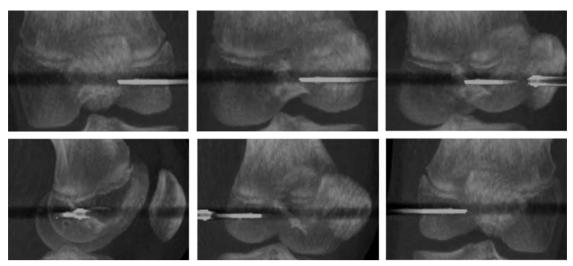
Intraoperative three-dimensional CT scan allows excellent visualization of the femoral and tibial tunnel placement relative to the physes. This allows the surgeon to evaluate tunnel placement in all planes to accommodate for the physes that undulate from front-to-back and side-to-side. The three-dimensional CT reconstruction shown above shows the guide pin in the distal femoral epiphysis rotating the image from left to right.
